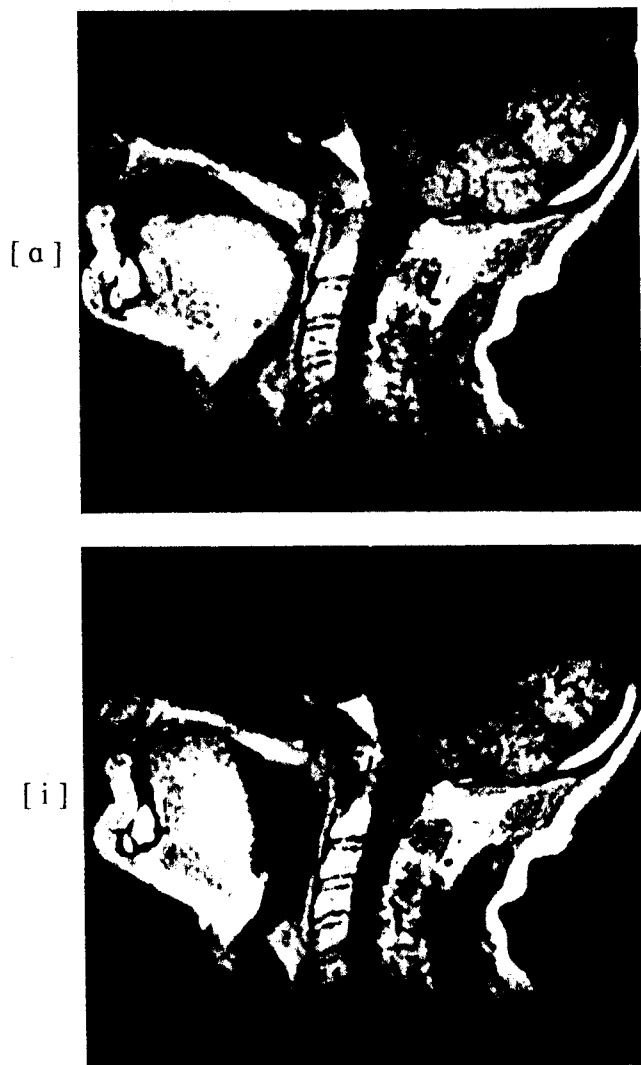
MRI images obtained from an adult male speaker producing the steady-state vowels [ɑ] and [i]. Figure courtesy of Patrick Nye.
